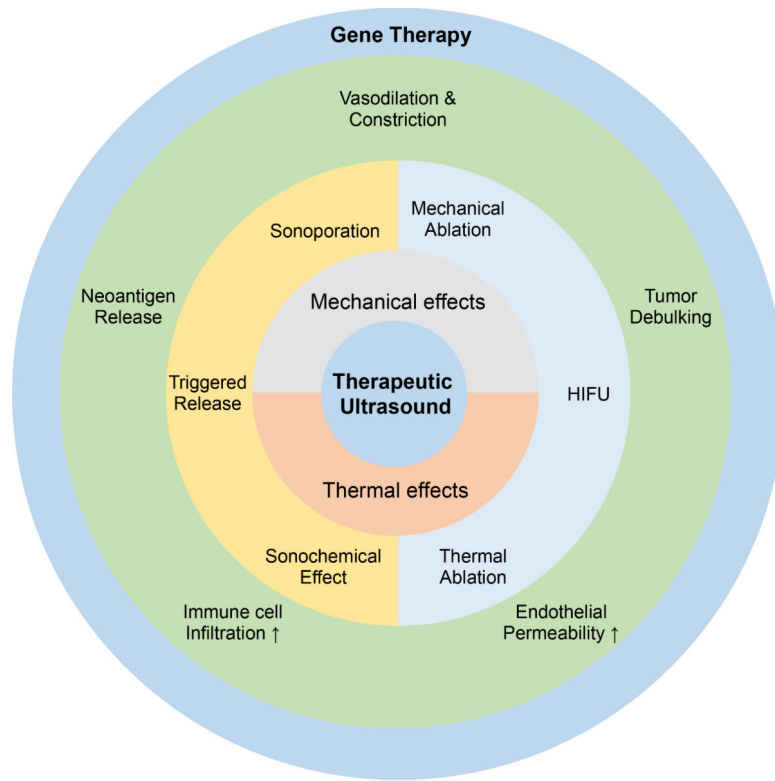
The mechanisms of therapeutic ultrasound in gene therapy, including mechanical and thermal effects with the induced biological effect in various aspects.
